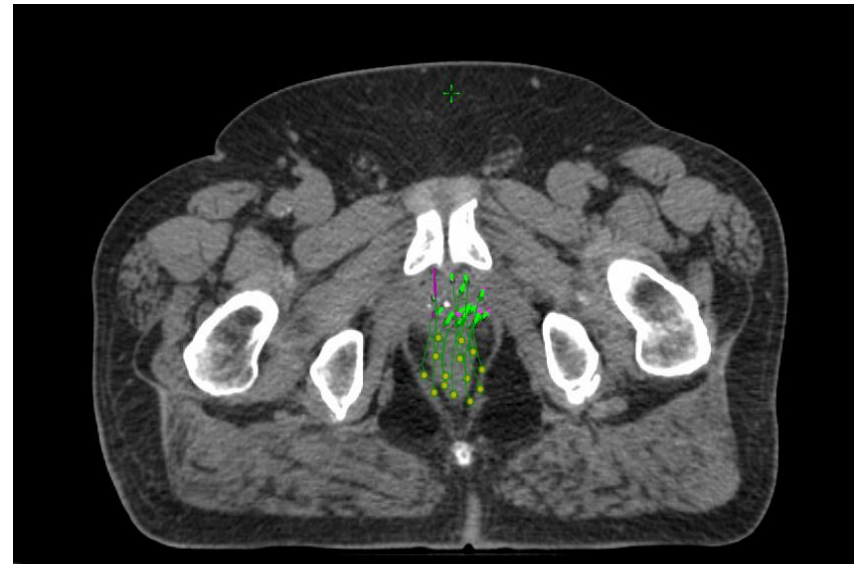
catheter reconstruction on CT
